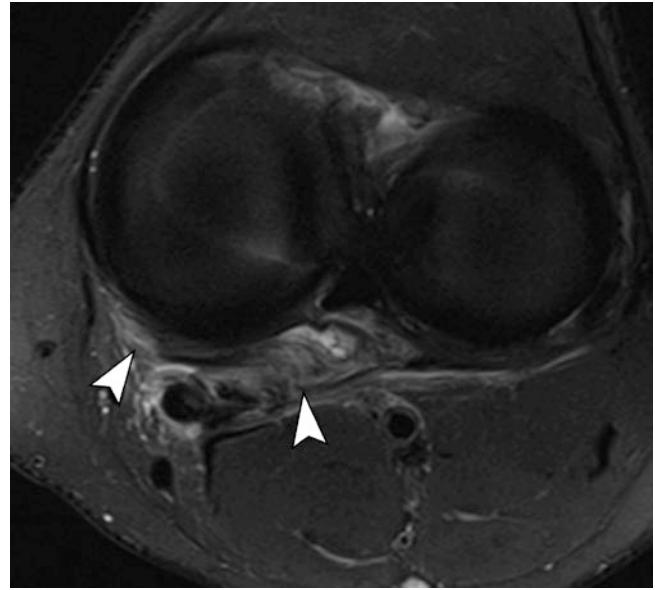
Oblique popliteal ligament tear. Axial T2-weighted image with fat suppression. Increased signal and thickening of the OPL (arrow heads)
